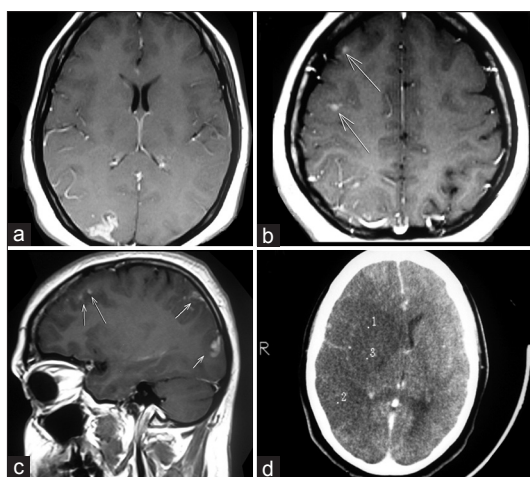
Tuberculous meningitis with arteritis leading to malignant middle cerebral artery (MCA) infarction. Gadolinium enhanced axial T1-weighted magnetic resonance images shows (a) enhancing leptomeningeal exudates with subcortical, juxta cortical and cortical granulomata in the right posterior parietooccipital region; (b) fronto-parietal cortical granuloma with leptomeningeal enhancement; (c) Fronto-temporo-parieto-occipital cortical, juxta cortical granuloma with leptomeningeal enhancement. (d) contrast enhanced computerized tomography (CT) axial image shows malignant infarct involving the entire right MCA territory with compression of the right lateral ventricle and midline shift to the left side. One and three marked regions in CT represent basal ganglionic region and two represent temporo occipital region with no significant hemorrhagic component
